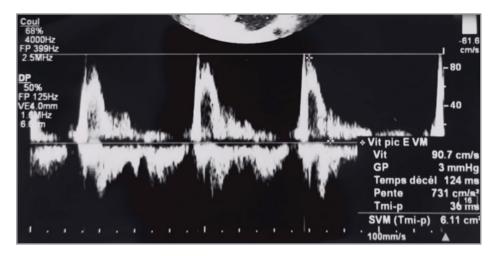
Doppler echocardiography revealing restrictive mitral inflow velocity.
